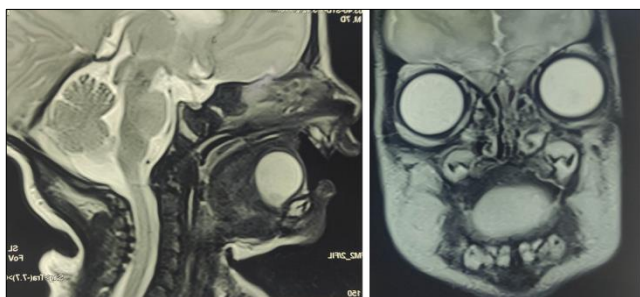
MRI showing a sublingual cystic lesion.
